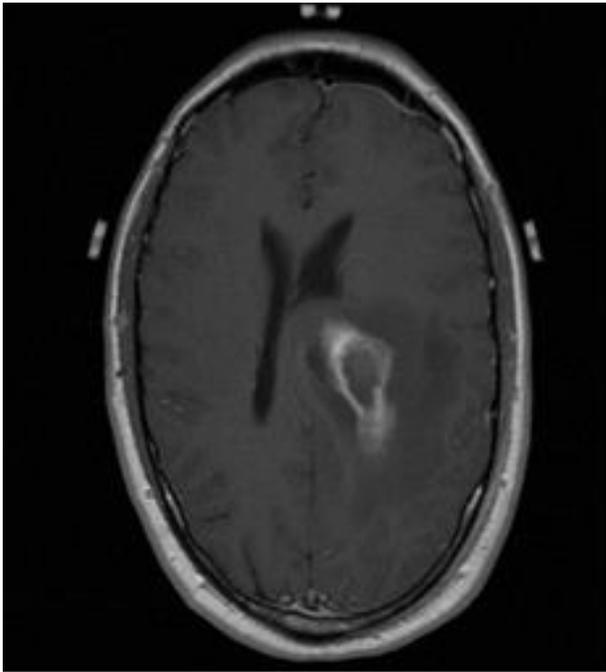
Series of benign tumours in brain MR images (Input images).
